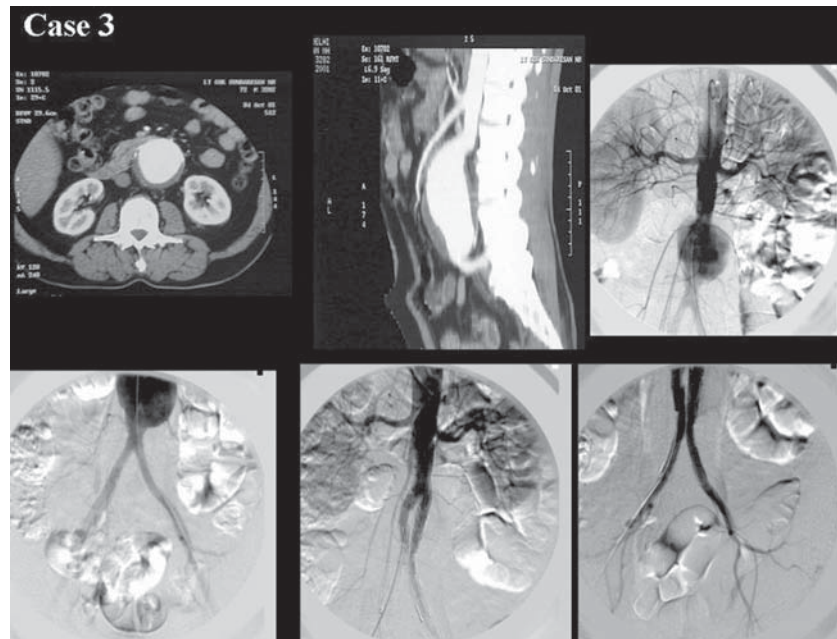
Case 3(Clockwise) 3(a,b) Contrast enhanced CT scan shows a large atherosclerotic aneurysm involving infra renal abdominal aorta involving the aortic bifurcation and tortuous right common iliac artery. 3(c,d) Digital Subtraction angiography outlines an infrarenal aneurysm. 3(e,f) DSA after successful exclusion of the aneurysm by bifurcated stent graft and a tubular extension
